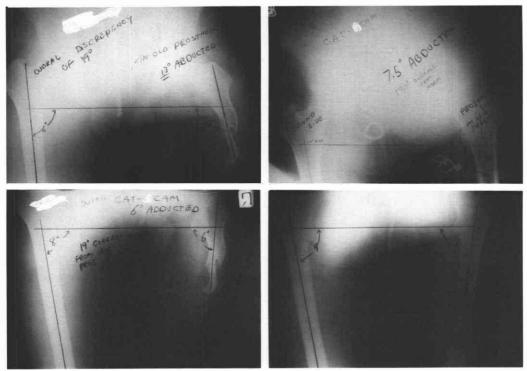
Weight bearing x-rays comparing CAT-CAM and quadrilateral sockets.
